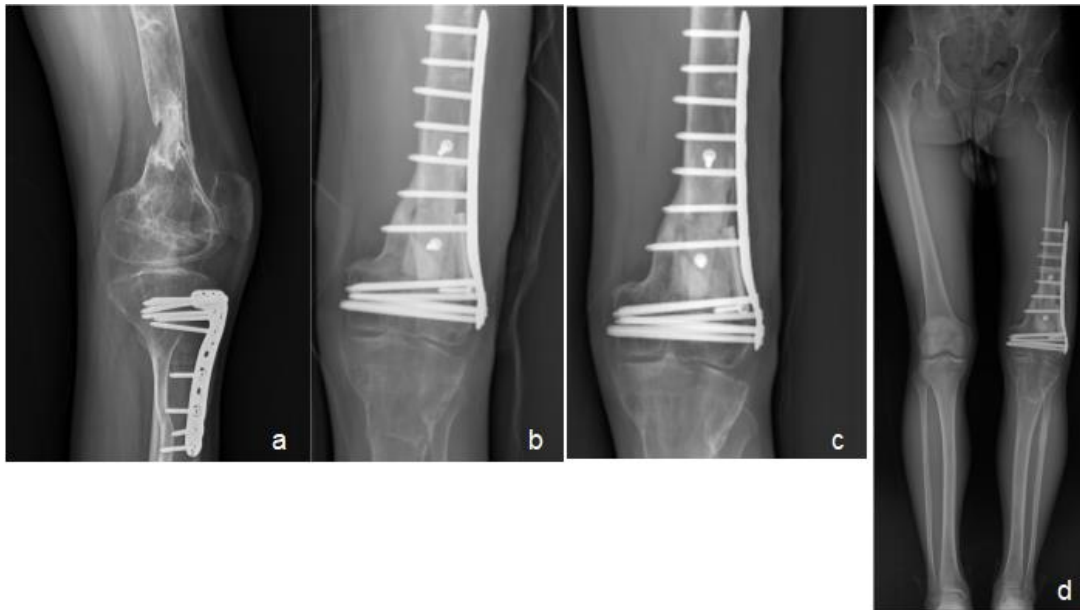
Application of the Technique. a Preoperative X-ray, b 2 days postoperative, c 3 months postoperative, d 7 months postoperative, e) 18 months postoperative.
